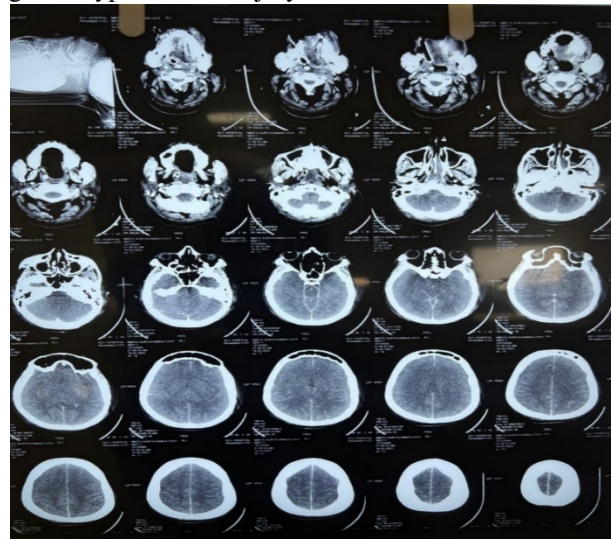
FIG Non-contrast CT Brain Showing Diffuse Cerebral Edema with Loss of Gray–White Matter Differentiation Suggestive of Global Hypoxic Injury
